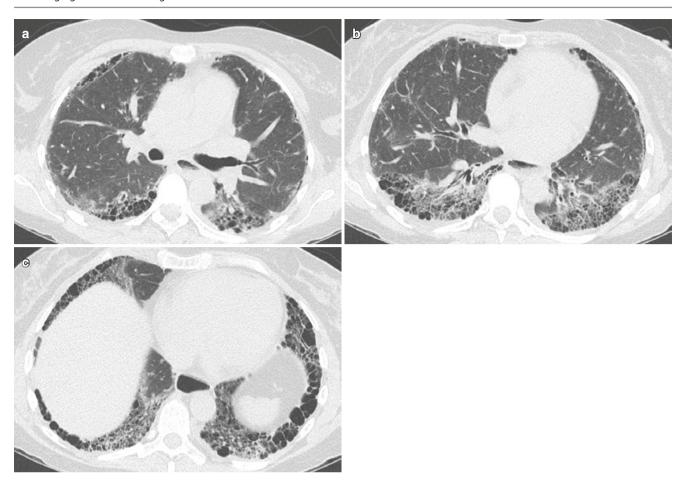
Scleroderma with UIP. (a-c) Axial CT images show UIP pattern with an air-fluid level in the dilated esophagus
